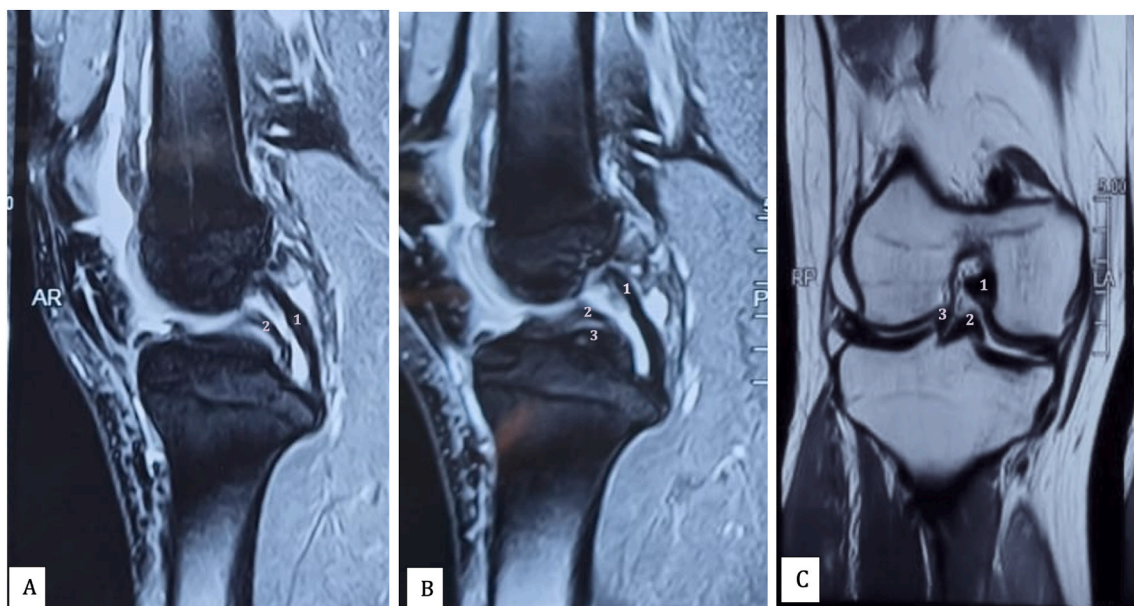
Magnetic resonance image (MRI) findings. A. Sagittal T-2 weighted showed the “Double-PCL sign” B. T-2 weighted showed the “Triple-PCL sign” on another sagittal slice, C. Coronal view of T-2 weighted showed the femoral notch with displaced meniscus (Triple-cruciate sign). (1 = normal PCL, 2 = flipped medial meniscus, 3 = flipped lateral meniscus).
